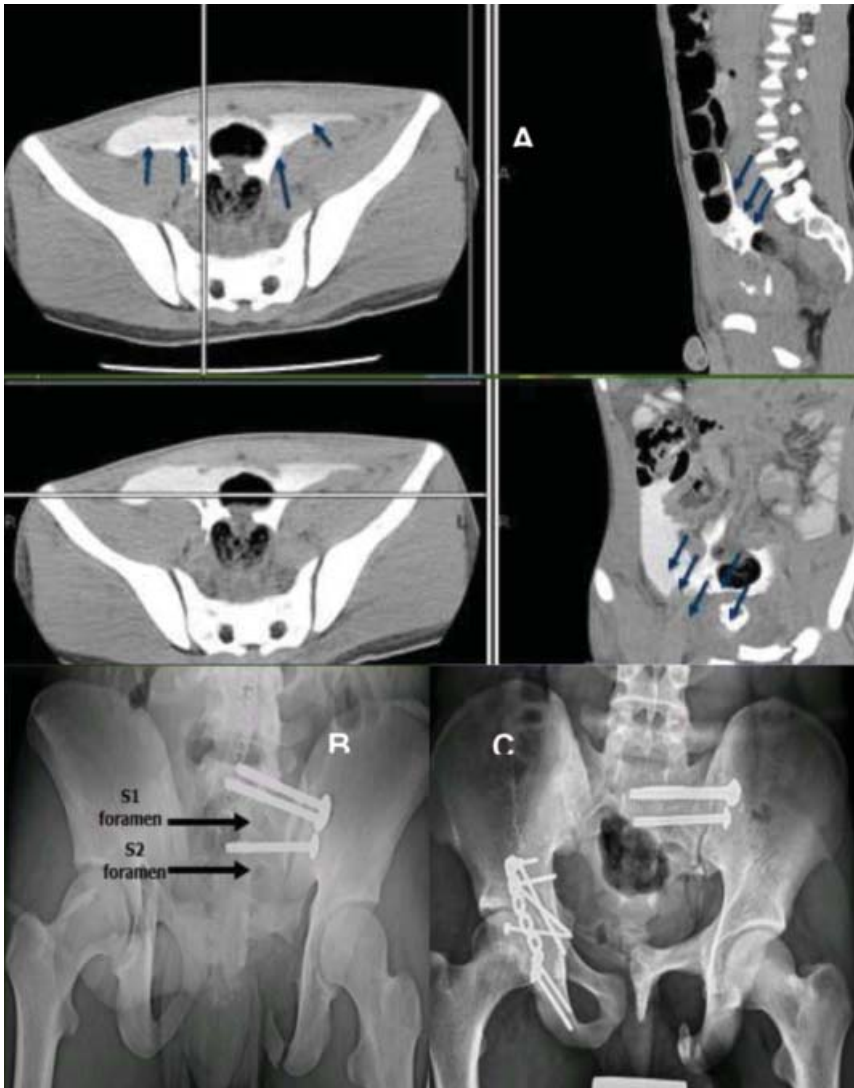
Same patient in figure 1. He had a fever spikes and abdominal tenderness while admitted in the special care unit. A: CT scan showing intraperitoneal extravasation of contrast and peritonitis due to ruptured bladder which was missed at time of presentation. This was controlled surgically followed by left sacroiliac joint and then acetabulum fixation as in the pelvis outlet view in B. C: Two years follow-up radiographs showing union of the fracture with preserved hip joint and head of femur.
